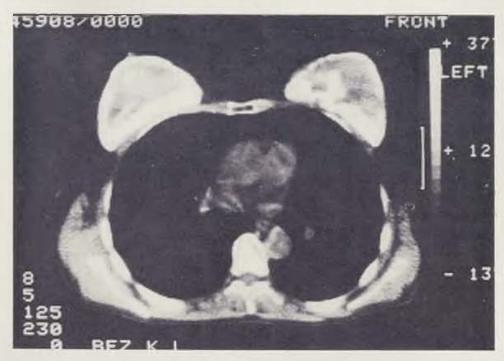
Patient M. P. CT check-up 18 years after hydron implantation. A coherent thick calcified layer is discernible around the whole of the implants
